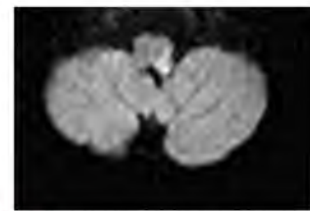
On diffusion-weighted magnetic resonance imaging, the left lateral medulla showed a high signal intensity.
